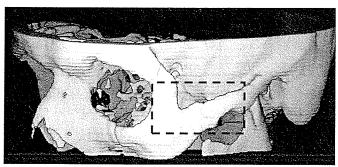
Post Test CT Image and Autopsy Photo Showing Injury for Test 2
